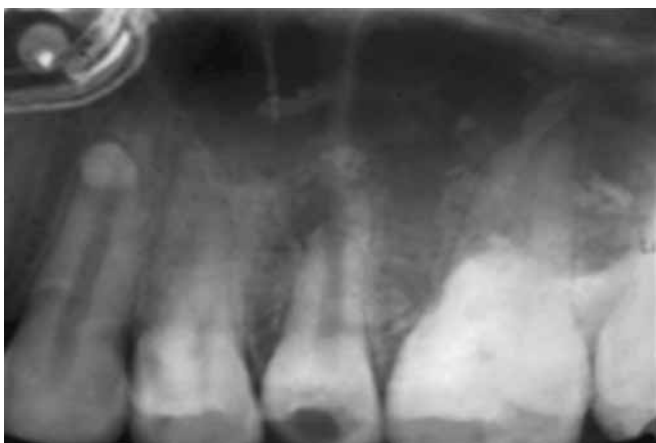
Preoperative radiograph (case 1)
